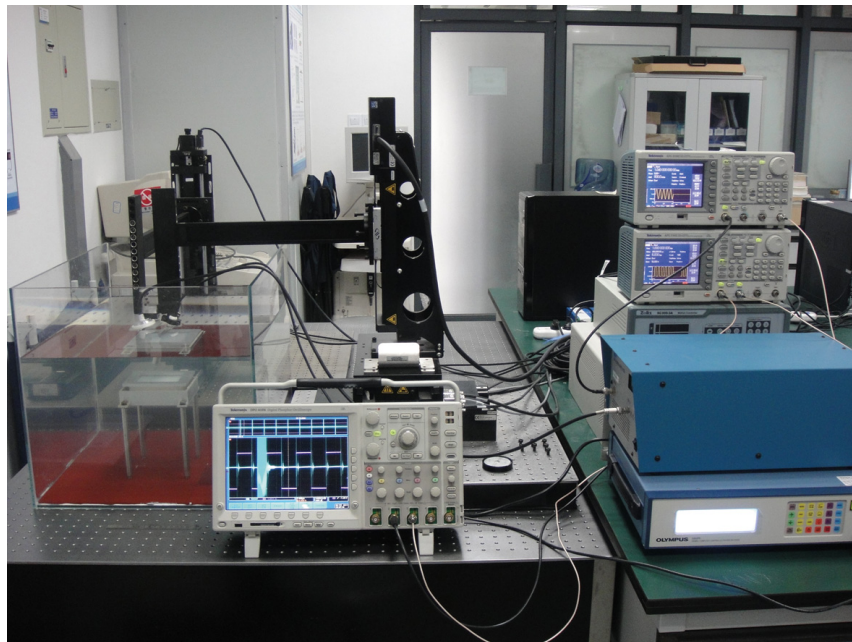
Ultrasound vibro-acoustic imaging research platform.
